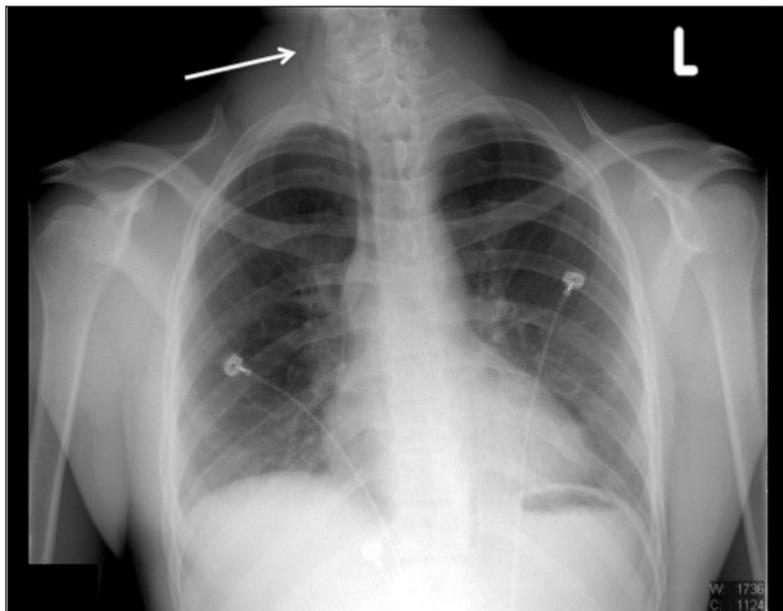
Radiograph of the chest. The white arrow indicates free air in the soft tissues of the neck.
